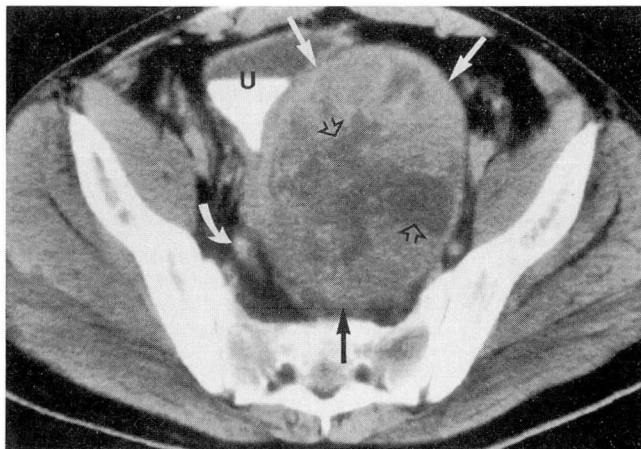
CT scan of the pelvis following administration of oral and intravenous contrast material reveals a large, enhancing, well-defined left retroperitoneal mass (solid arrows) which contains areas of low attenuation (open arrows). The urinary bladder (U) and rectosigmoid colon (curved arrow) containing contrast material are displaced by the mass.
